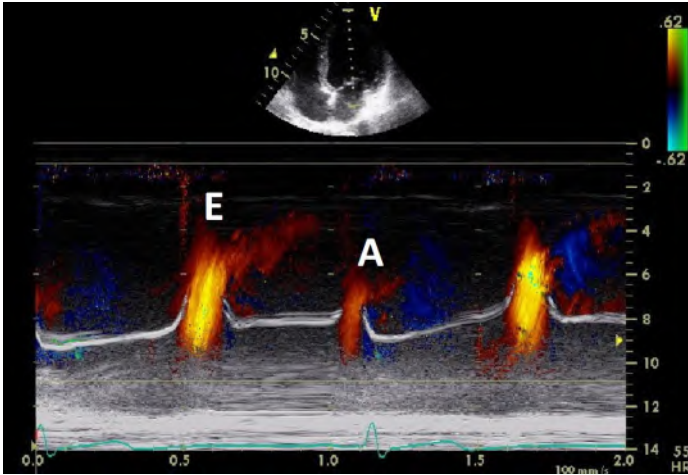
Colour Doppler M-mode scan of the mitral inflow. Ventricular filling of a healthy subject showing mitral flow velocity of the early rapid filling wave (E) and flow velocity of the late filling wave caused by atrial contraction (A).
